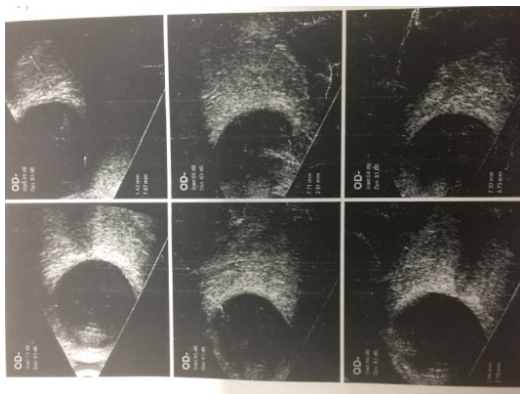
Extraocular muscle thickening (OD) of the above patient on B scan ultrasonography
